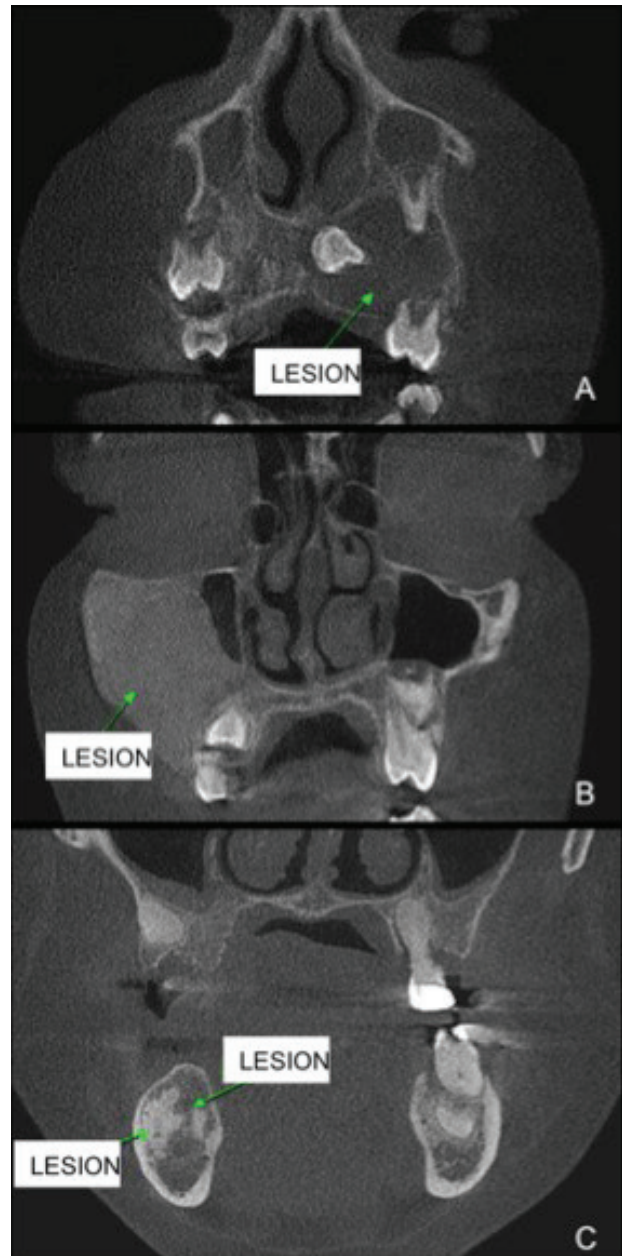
CBCT sagittal cuts evidencing: (A) tooth expulsion due to the lesion; (B) External root resorption. (C) Axial cut exemplifying a lesion with bulging, thinning, and discontinuity of the corticals.
